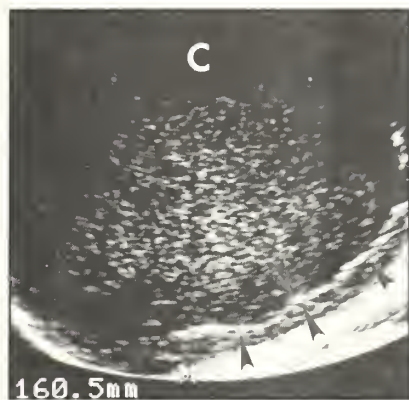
Sonography shows mixed echogenicity of the cyst (C) and focal bright echoes representing calcification in the capsule (arrowheads).
